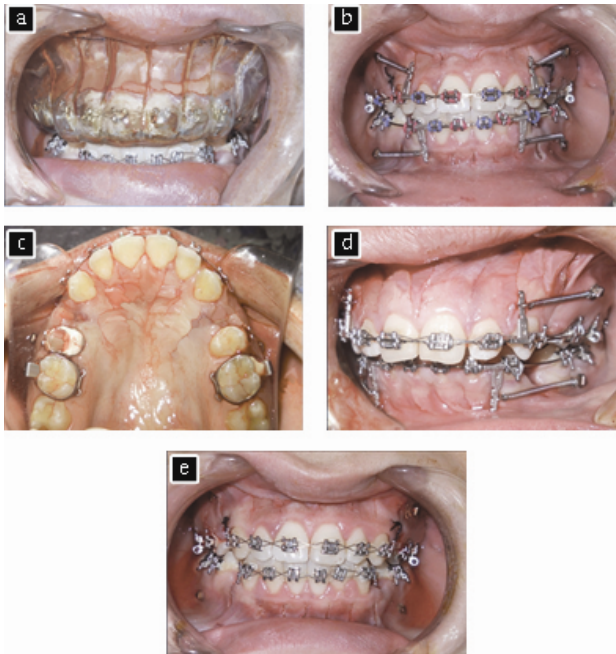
(a) Clinical photograph showing the cone beam surgical guide in patient's mouth and the incision for vertical cut marked; (b) Clinical photographs showing buccal view of the vertical cut in the upper and lower jaws; (c) Clinical photograph showing palatal view of the vertical cut in the upper jaw; (d, e) Clinical photographs showing final view after the operation and activation of the appliance.
